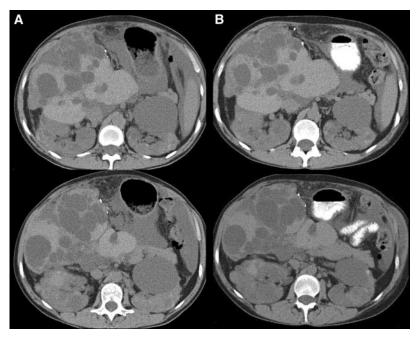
Administration of octreotide LAR to a patient with severe PLD resulted in decreased liver and kidney volumes. CT axial sections immediately before (A) and after 8 months of treatment with octreotide (B) are shown. Total liver volume decreased by 18% from baseline, and total kidney volume decreased by 12%.
